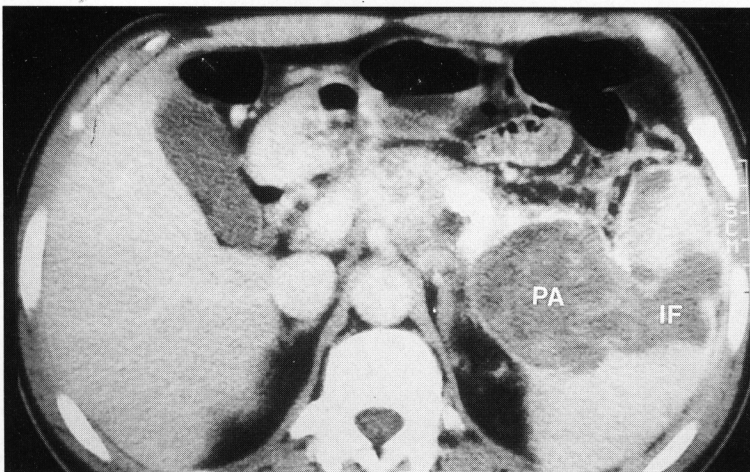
Abdominal CT scan shows a round cystic lesion (PA) measuring approximately 8 × 7 cm in the tail of pancreas and multiple hypodense lesions (IF) in spleen. PA : Pseudo aneurysm, IF : Infarction
